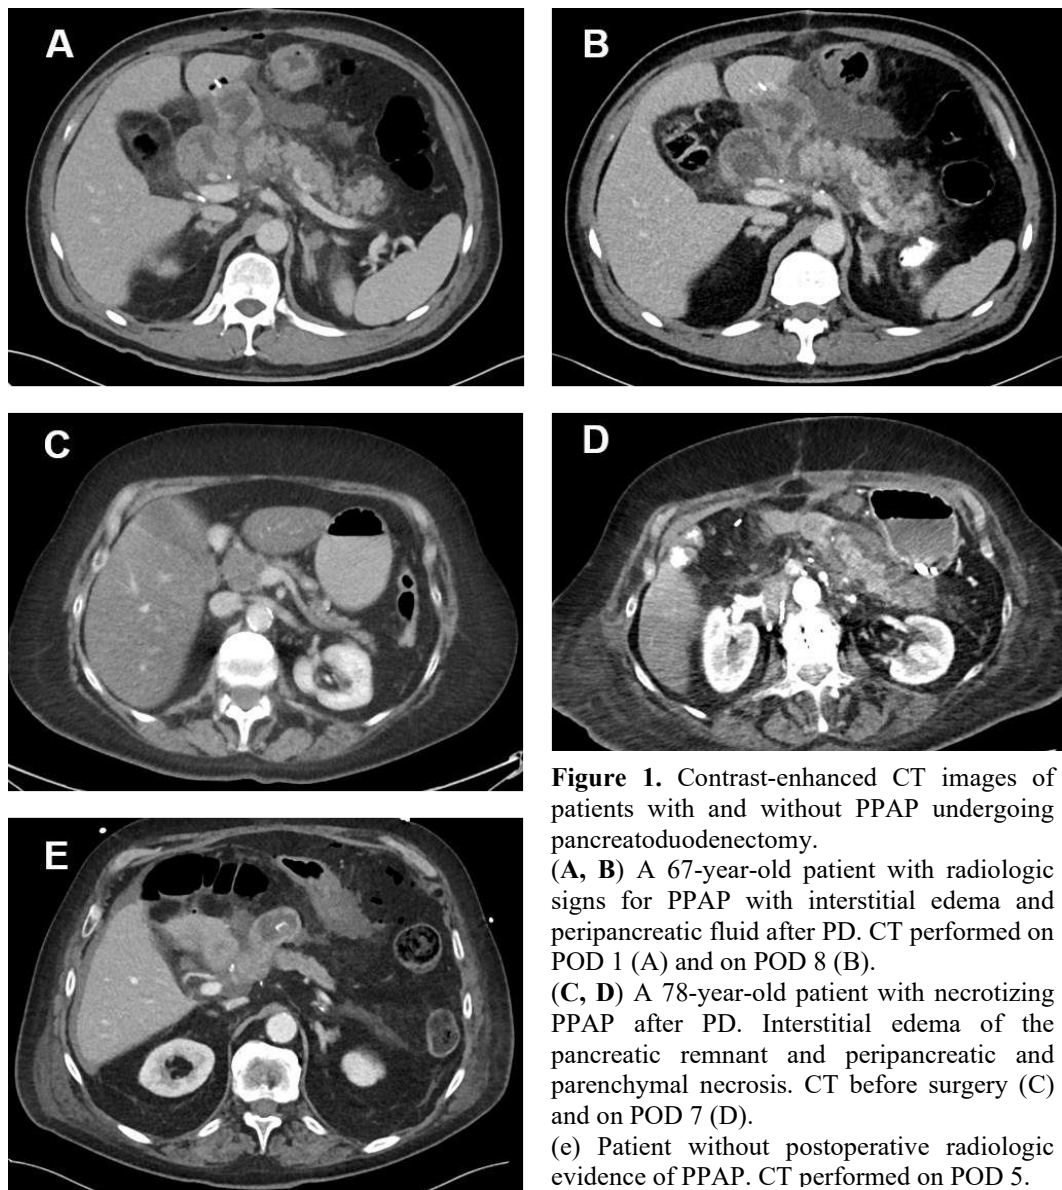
Contrast-enhanced CT images of patients with and without PPAP undergoing pancreatoduodenectomy.
